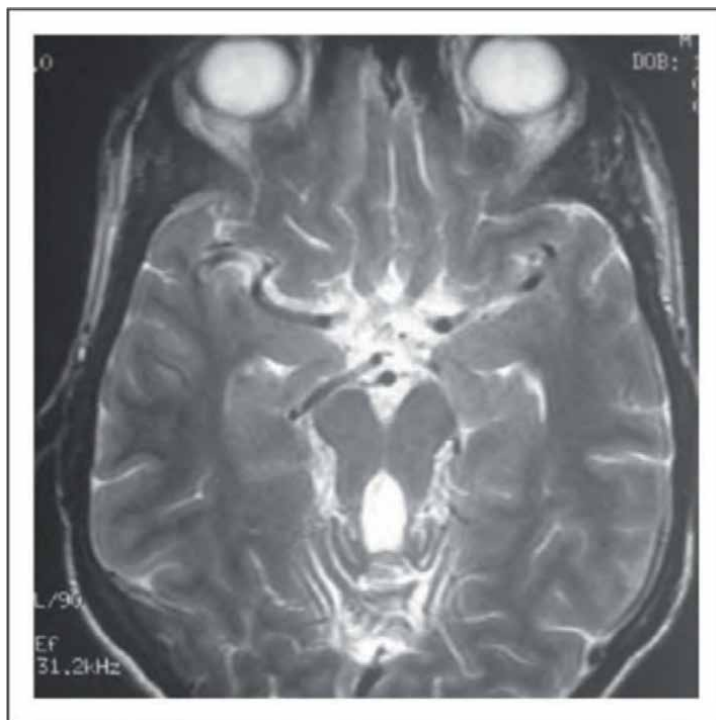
T2-weighted, axial image of a brain MRI in a patient presenting Joubert's syndrome and the molar tooth sign [23].
